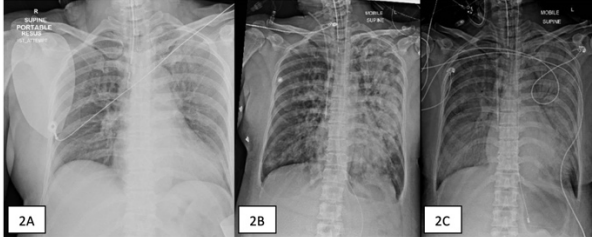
Chest radiographs performed on Day 1 (2A), Day 2 (2B) and Day 3 (2C) of injury.
